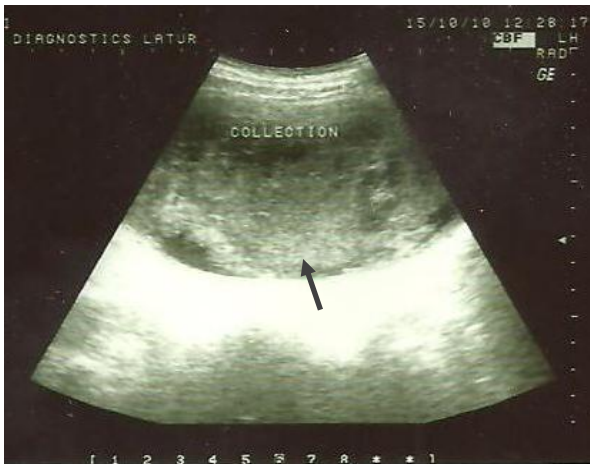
Ultrasonography abdomen showing a solitary cystic, mass containing debris
